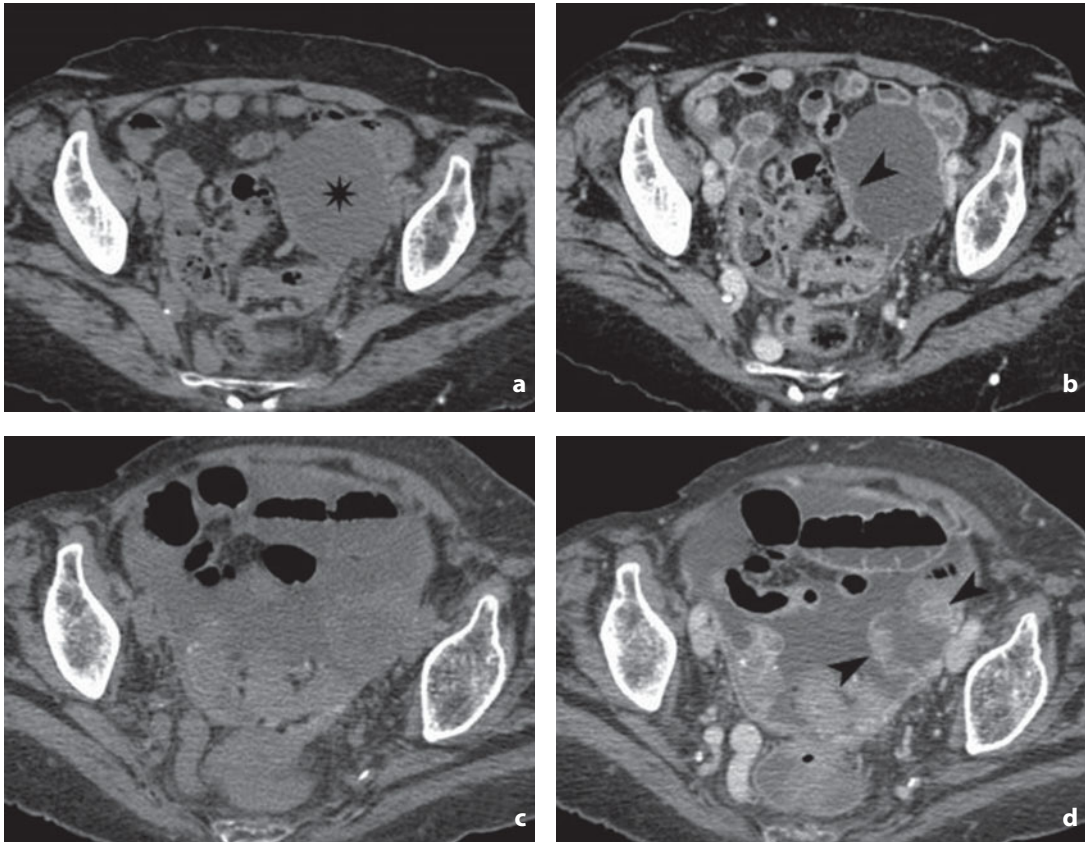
Computed tomography. Endometrioid adenocarcinoma. a Nonenhanced CT. Oval-shaped left adnexal mass (asterisk) with fluid content and wall thickening medially. b After contrast medium administration mild enhancement of the thickened wall can be identified (arrowhead). The patient did not undergo surgery due to severe heart disease. c At CT follow-up the nonenhanced image shows the lesion with diffusely irregular and thickened walls and the appearance of ascites. d Contrast-enhanced image shows marked enhancement of the walls with intracystic and exophytic nodulations (arrowheads). The malignancy is better visualized due to the presence of ascites
